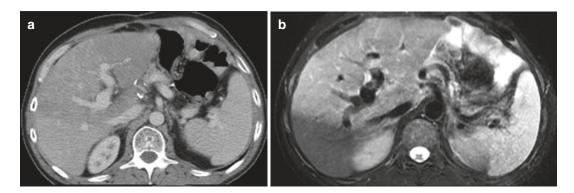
A patient with breast carcinoma with a history of radiation therapy. A well-demarcated hypodense area on contrast-enhanced CT image (\mathbf{a}) and hyperintense area on T2W image (\mathbf{b}) that are consistent with radiation port are seen
